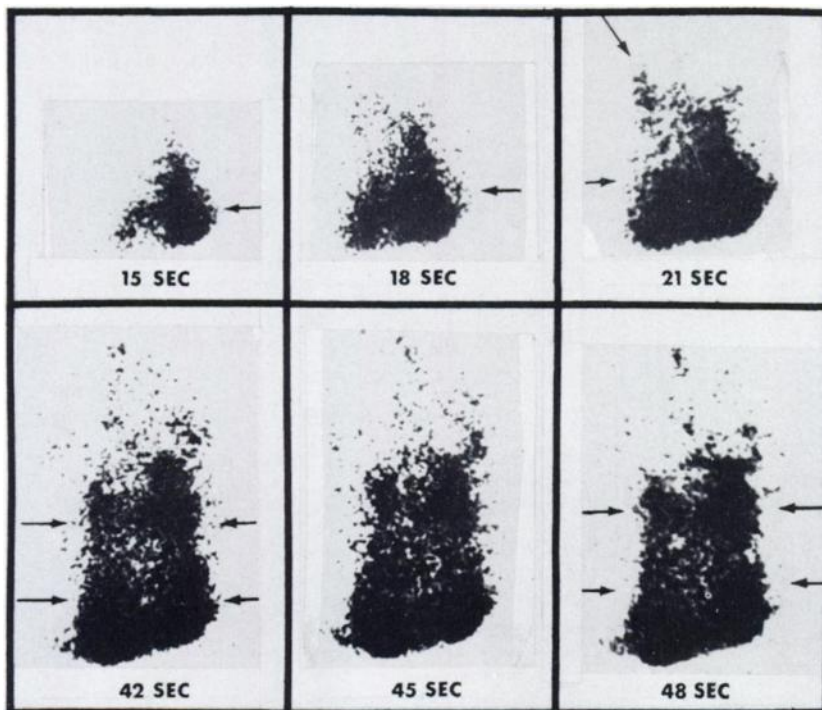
Rapid-sequential brain scintigrams in 80-year-old patient. Anterior projection. Note persistence of extremely high concentration of radioactivity in cervical region (lower arrows). Middle cerebral artery (descending arrow) is best seen at 21 sec. Cervical veins (upper arrows) appear both early (15 sec) and late (42, 45, and 48 sec).
